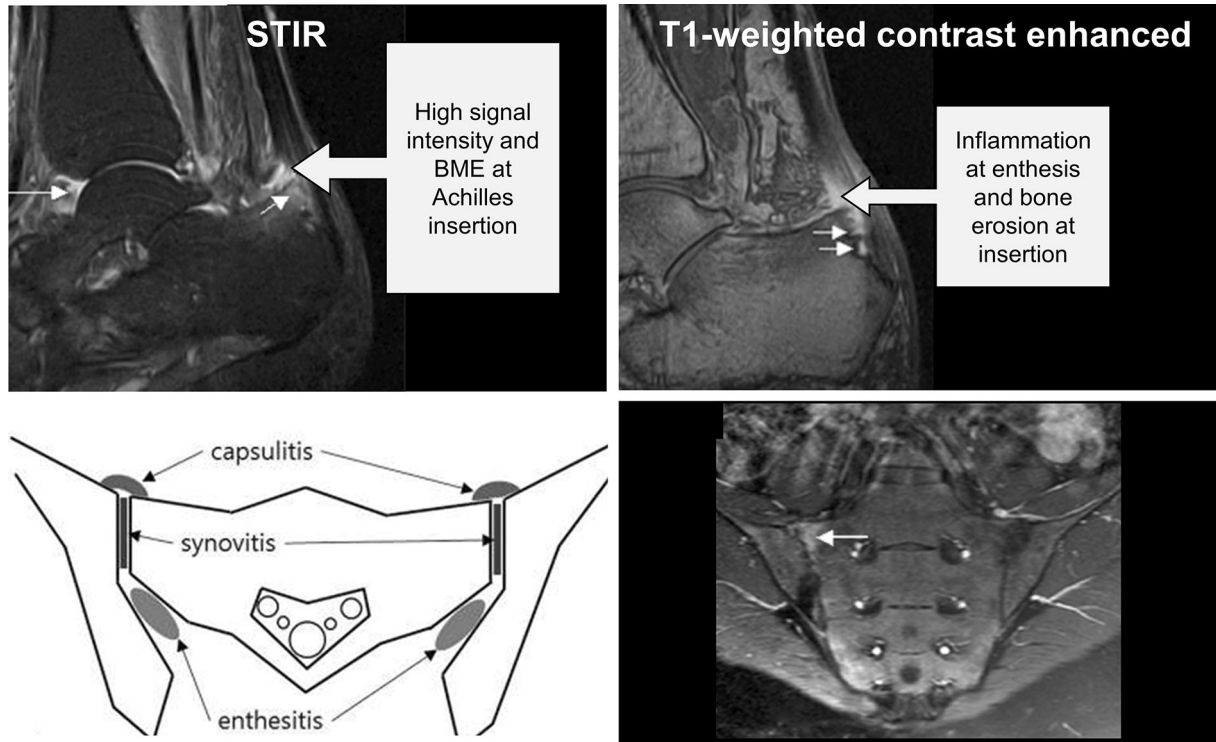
Imaging of entheses by MRI. *Top*: soft tissues of the entheses visualized by MRI. *Bottom left*: enthesitis, synovitis, and capsulitis in sacroiliac joint. *Bottom right*: T1-weighted semicoronal MRIs through the sacroiliac joints after intravenous contrast injection. Enhancement is seen at the right sacroiliac joint (*arrow*), indicating active sacroiliitis. *BME* bone marrow edema, *MRI* magnetic
